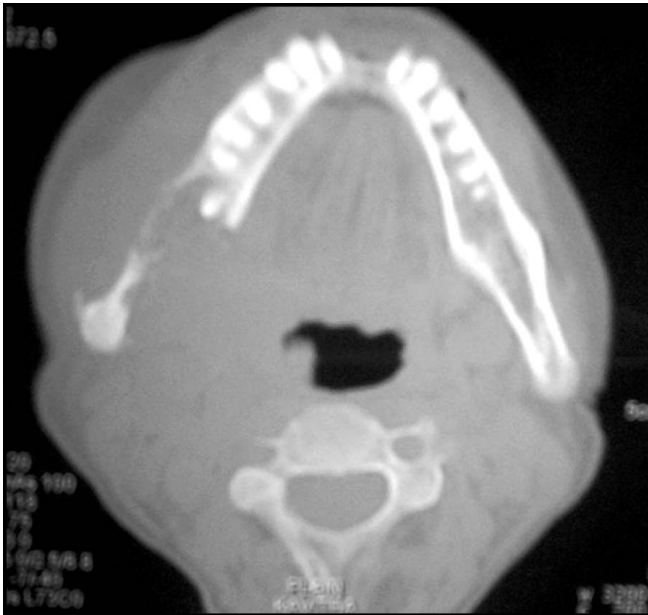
Shows axial CT picture of Fig. 18.8F with destruction of the ramus and posterior body of mandible
